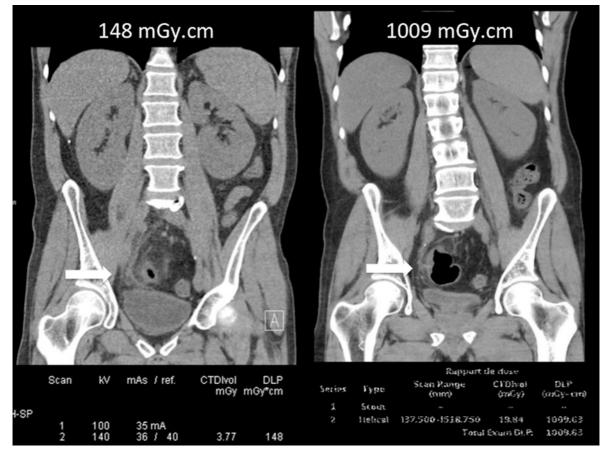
Comparison of two consecutive unenhanced MDCT in a 48-year-old man weighting 75 kg who had a sigmoid perforation on a foreign body that proved to be a swallowed toothpick. The toothpick is visible on the right-sided coronal reformat but had not been seen by the local radiologist who acquired the CT at 120 kV and a noise index of 10 UH for 1.25 mm slices. The resultant CTDIvol is at 19.84 mGy and the DLP is of 1.009 mGy.cm. The second scan displayed on the left
